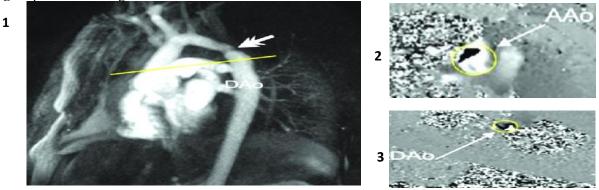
Bicuspid aortic valve disease and aortic coarctation on 2D CINE PC-MRI with interference (1 to 3)
